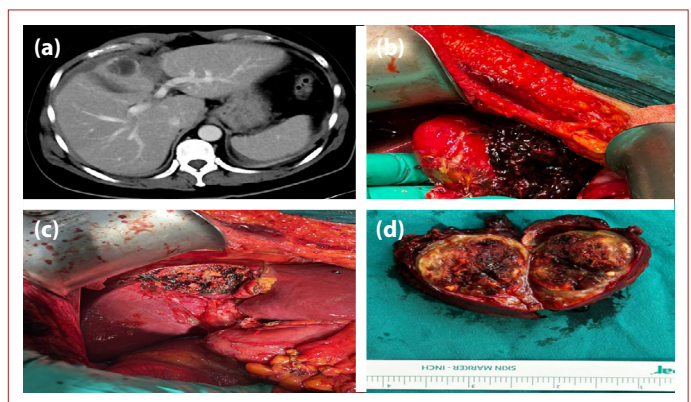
Post-embolization control CT slice (a) demonstrates necrosis of the tumor (b) and the decrease in the amount of perihepatic hemorrhage. Central hepatectomy (c) and macroscopy of the tumor (d).
